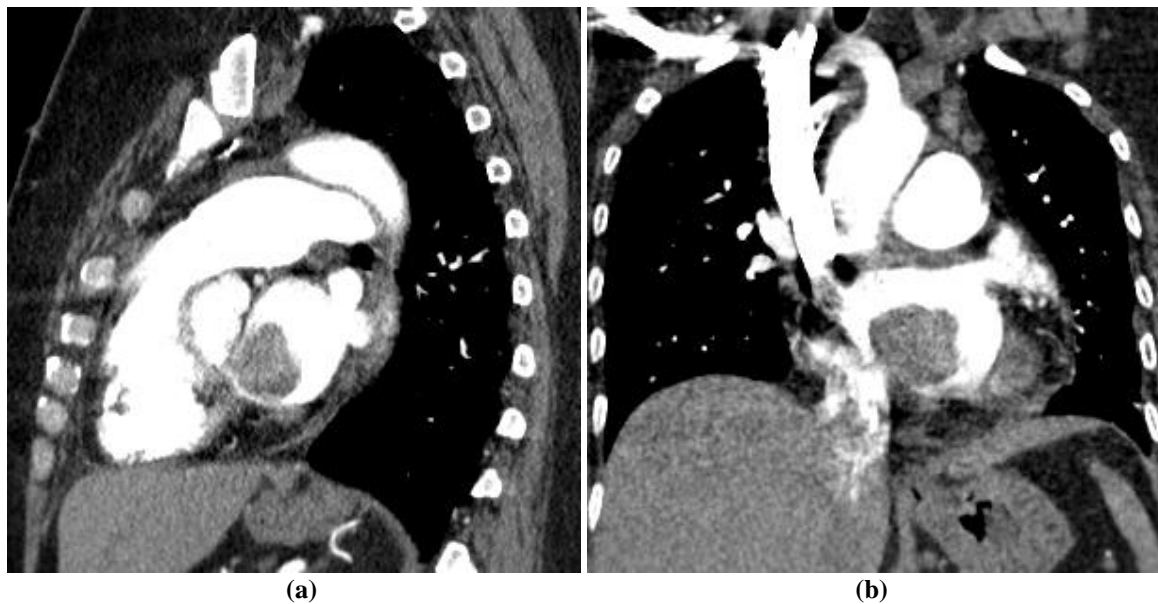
Cardiac CT sagittal (a) and coronal (b) images shows hypodense non enhancing polypoidal mass in left atrium.
